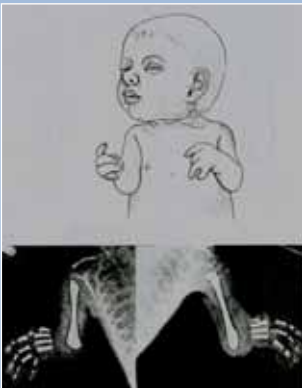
Xray showing bilateral agenesis of radius and ulna.
